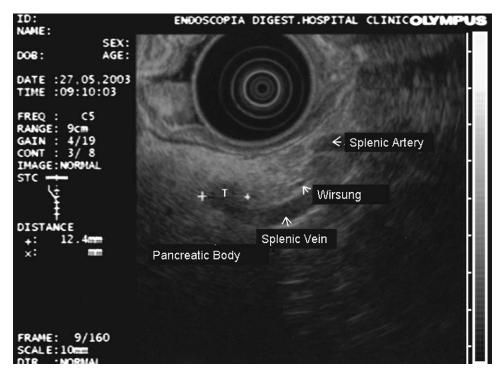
Endoscopic ultrasonography showing 1 cm tumor (T) in close proximity to the splenic vein and Wirsung duct.
